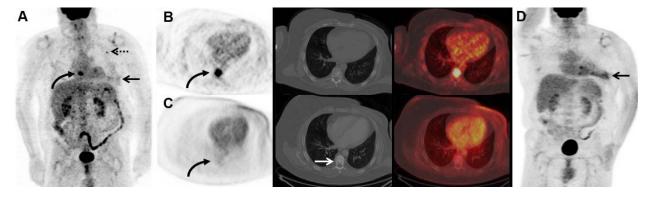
53-year-old man with a pre-PET/CT stage IIB breast cancer, which was upstaged to stage IV by <sup>18</sup>F-FDG PET/CT. (A) <sup>18</sup>F-FDG MIP image demonstrates FDG avidity in the left breast (arrow), left axilla (dashed arrow), as well as overlying the midline chest (curved arrow). (B) Axial FDG PET, CT on soft tissue window, and fused FDG PET/CT demonstrate the FDG-avid known primary left breast malignancy (arrow). (C) Axial FDG PET, CT on soft tissue window, and fused FDG PET, CT on soft tissue window, and fused FDG PET, CT on soft tissue window, and fused FDG PET/CT demonstrate the FDG-avid known left axillary nodal metastases (dashed arrow). (D) Axial FDG PET, CT on bone window, and fused FDG PET/CT demonstrate FDG avidity in the midline chest on the MIP image corresponding to a thoracic vertebra without CT correlate. This lesion was biopsied and proven to be a previously unsuspected osseous metastasis, increasing the patient's stage to IV. This altered the patient's management from surgical management to systemic therapy without surgical management.
